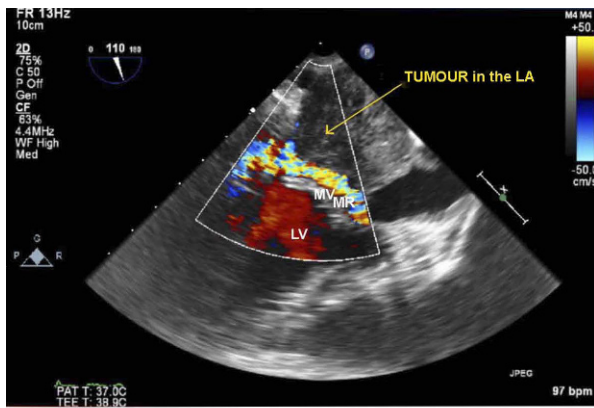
Two-dimensional trans-oesophageal echocardiography of the tumor in the left atrium (LA). LV, left ventricle; MV, mitral valve; MR, mitral regurgitation.
